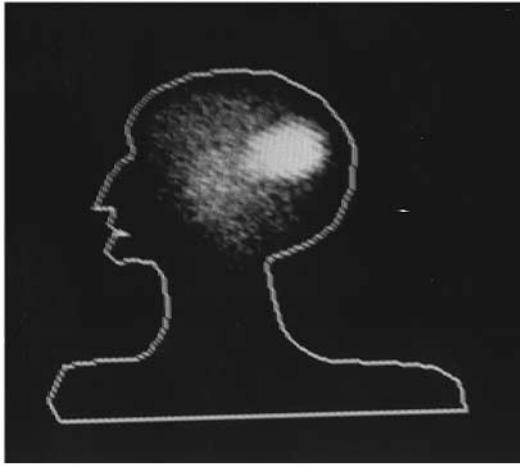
This patient (female, 54 years old) had malignant glioma in the right parietal lobe, which relapsed after the first operation in October 1994 and subsequent external radiotherapy. She had repeat surgery on April 1995. A fistula between the surgical crater and the right lateral ventricle was produced. She received four LR-RIT treatments. The scintigraphy obtained 7 days after the injection of the first therapeutical dose (I-131 2257 MBq) shows a dispersion of radioactivity in the right lateral ventricle. However, considerable radioactivity remained in the site of the lesion, demonstrating a preferential targeting of the tumour by means of specific MAbs. Seven months later, the patient presented a second GBL mass in the temporal lobe, distant from the primary lesion. Her survival was 21 months from diagnosis and 14 months from the first course of LR-RIT.
